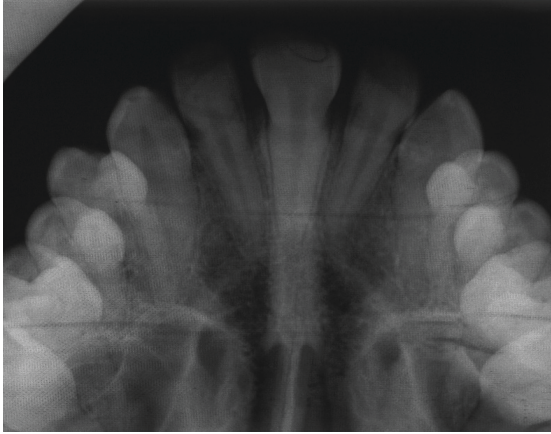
Patient's maxillary occlusal radiography.
